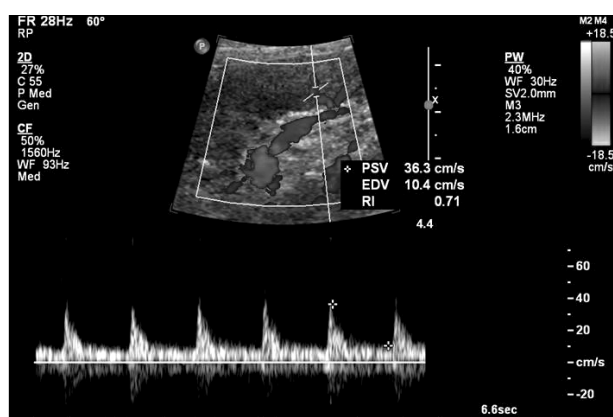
Follow-up color Doppler ultrasonography showing normal resistive index and flow pattern in the intrarenal artery.
